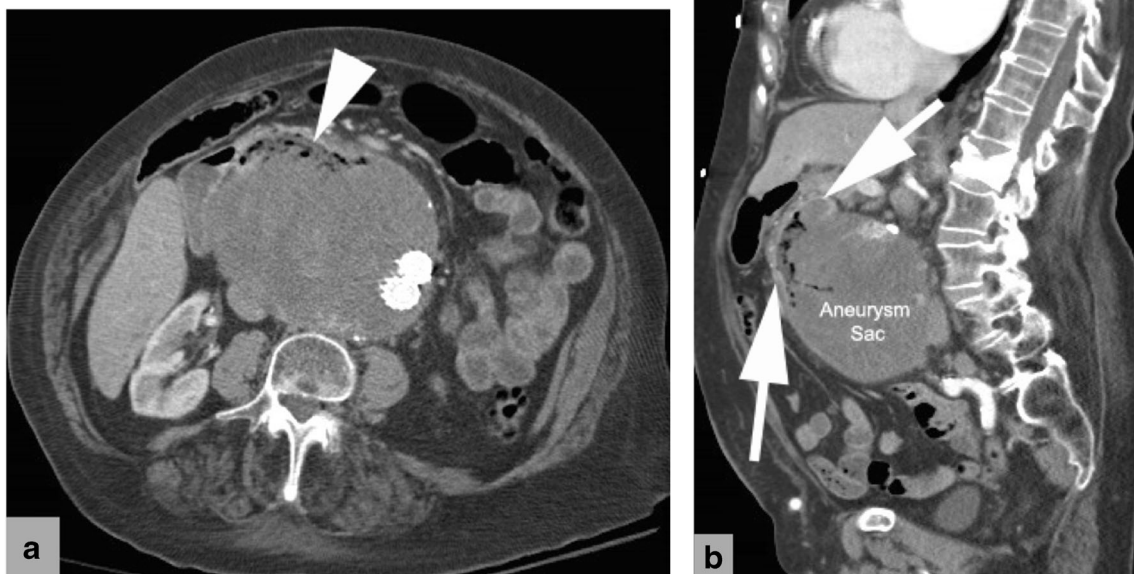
Rare complication of abdominal aortic aneurysm of the excluded sac, which can occur before and after repair if EVAR is complicated by refractory endoleak. a Axial and b sagittal MPR IV contrast-enhanced CT of an 87-year-old female with abdominal aortic aneurysm
